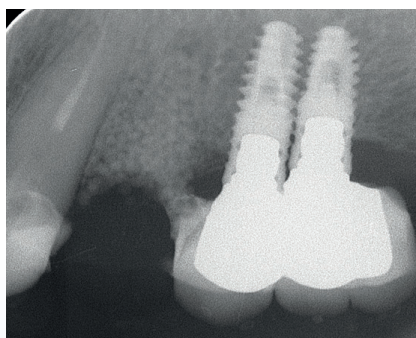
Control X-ray after ridge preservation.
